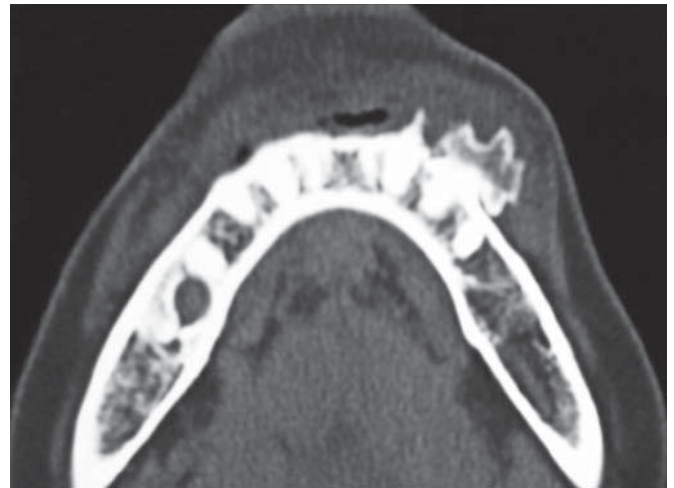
Exophytic bony lesion on left body of mandible in continuity with cortical bone (CT scan—sagittal view)
